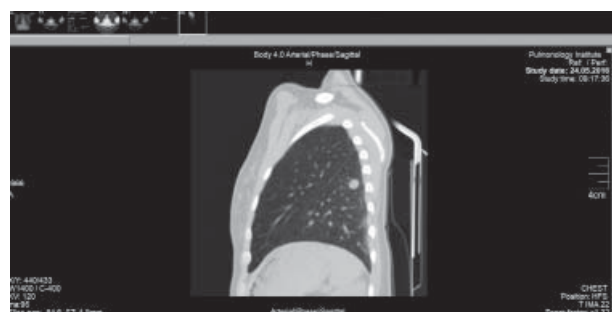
X-ray of the patient at the initial request for help, lateral projection
